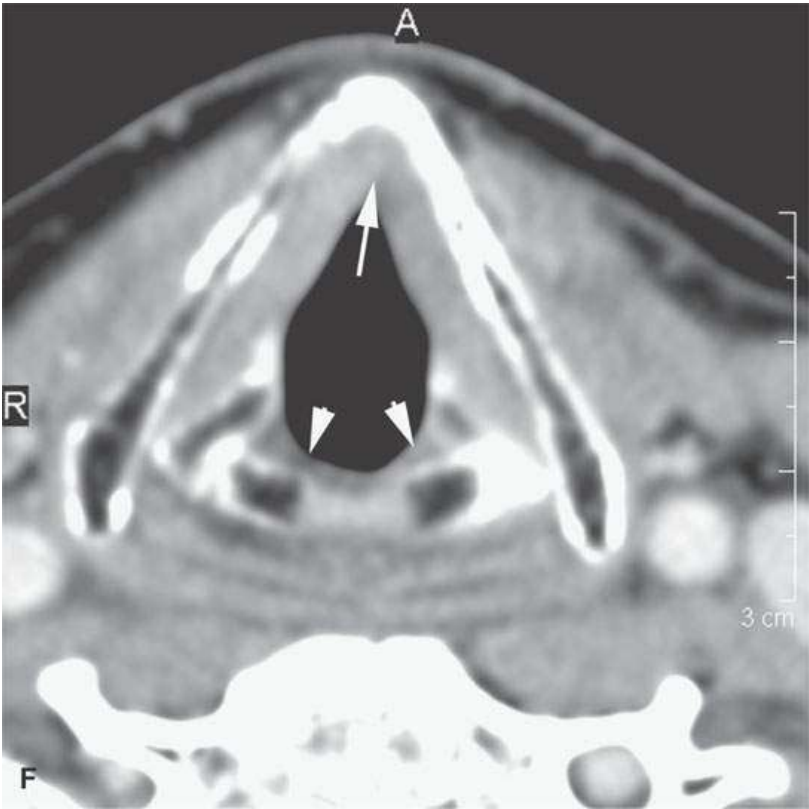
Contrast-enhanced computed tomography about 6 weeks after the completion of radiotherapy (RT) for squamous cell carcinoma of the tongue base. A–C: Enhancement of the salivary tissue, both major and minor, throughout the upper aerodigestive tract (*arrows*) and of radiation-induced mucositis (*arrowheads*) is a common finding up to about 3 months following the completion of RT. D: Salivary tissue (*black arrows*) and mucositis (*black arrowheads*) are
